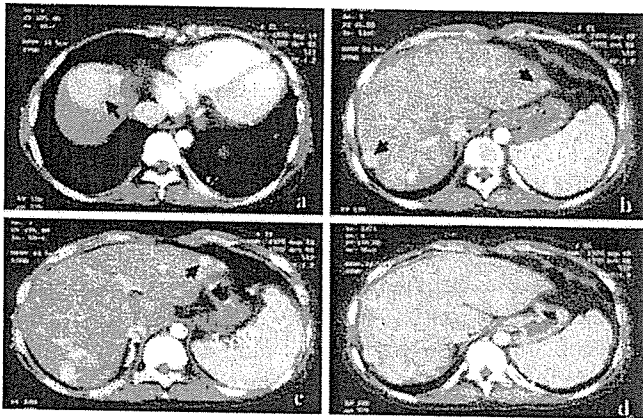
Abdominal computed tomography (CT) scans. a Space-occupying lesion (SOL), 45 mm in size, in S8 of the liver, which was enhanced in the early phase (*arrow*). b SOLs, one, 20 mm in size, in S7/8 of the liver, and one, 10 mm in size, in S3 of the liver, which were enhanced in the early phase (*arrows*). c SOL, 12 mm in size, in S3 of the liver, which was enhanced in the early phase (*arrow*). d In the portal phase, the liver parenchyma was spottily enhanced
